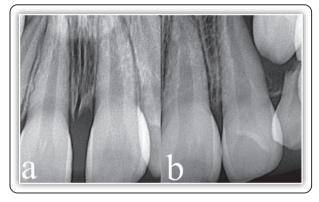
Periapical radiographs showing normal interproximal bone level around the recovered LMCI from (a) mesial and (b) distal aspects.
